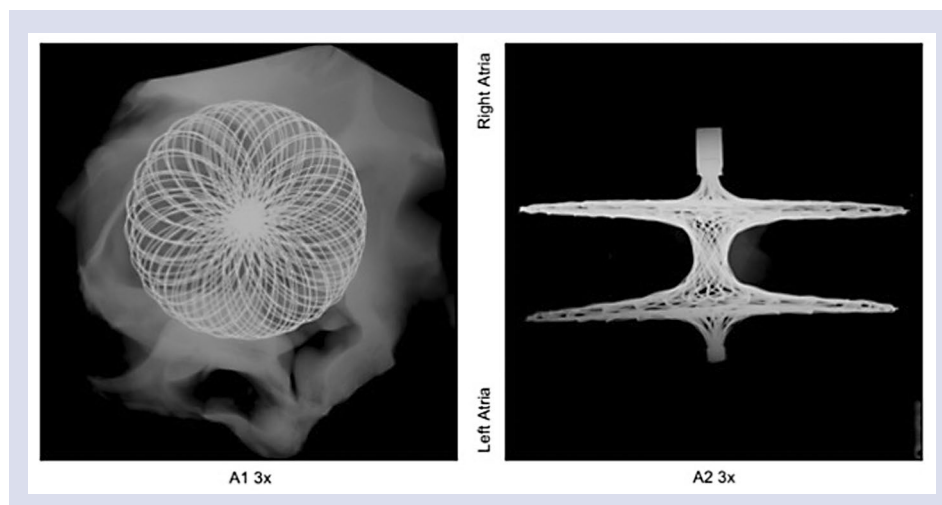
High-resolution radiography of tested occluder at 90-day follow-up. All nitinol portions of the frame appeared intact and breaks were not detected. Overall, the device appeared to be well deployed in the atrial septum. The right and left sides of the nitinol frame were parallel to each other, and the connector, which crossed the septum, was perpendicular to the two sides of the device
